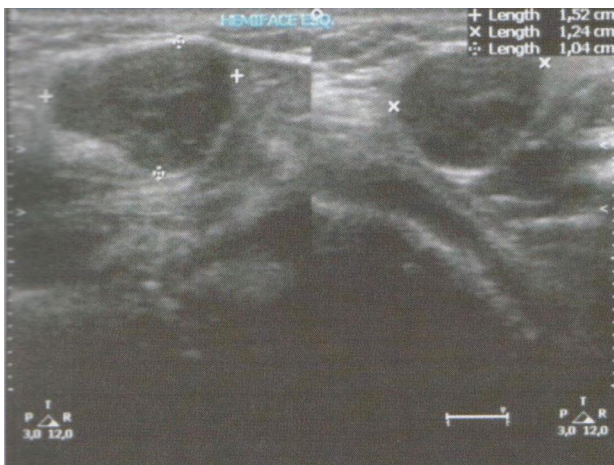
Ultrasonography revealed a lesion measuring, approximately, 1.5 x 1.2 x 1.0 cm.
